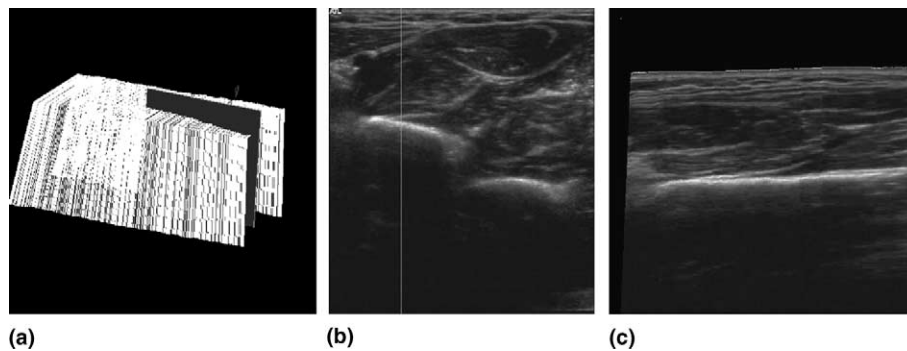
Arm ultrasound sequence: (a) ultrasound sequence and reslice image in 3D space; (b) classical B-scan; (c), reslice image using StradX software (Prager et al., 1999).
